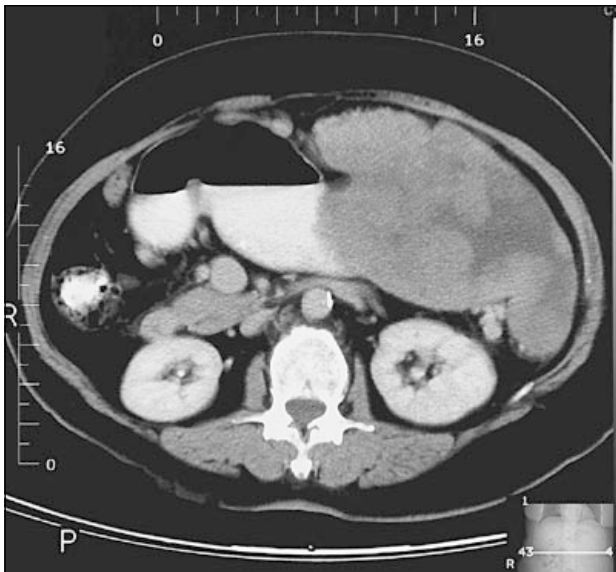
Exophytic gastric stromal tumour in a 65-year-old woman presenting with a palpable left abdominal mass and gastrointestinal bleeding. CT abdomen revealed a large exophytic mass along the greater curvature of the stomach.
